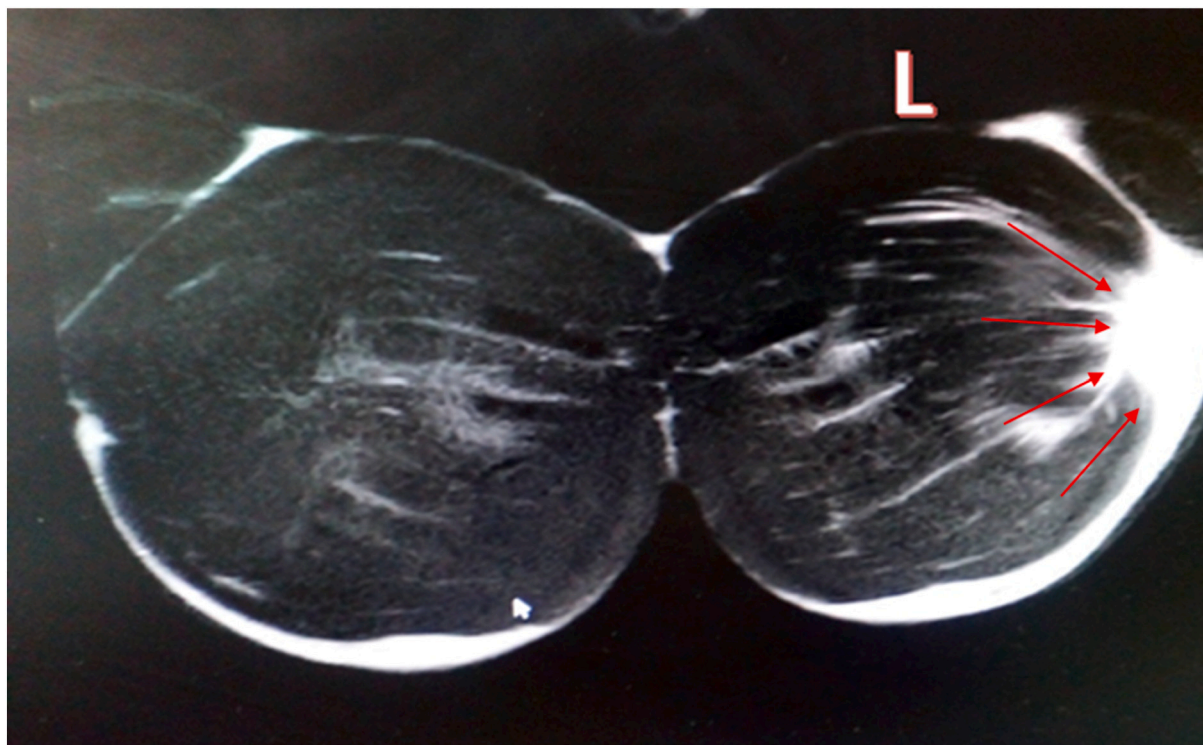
Coronal MRI T2 shows the clear tear in the musculotendinous junction of the sterno-costal part of the left Pectoralis Major muscle in comparison to the right one (red arrows). (For interpretation of the references to colour in this figure legend, the reader is referred to the web version of this article.)
